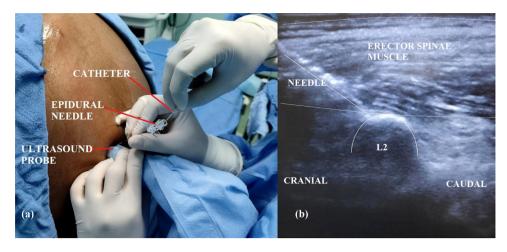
(a) Ultrasound-guided erector spinae block with catheter insertion in a sitting position. (b) Ultrasound image of erector spinae block showing needle, L2 vertebrae, and erector spinae muscle.
